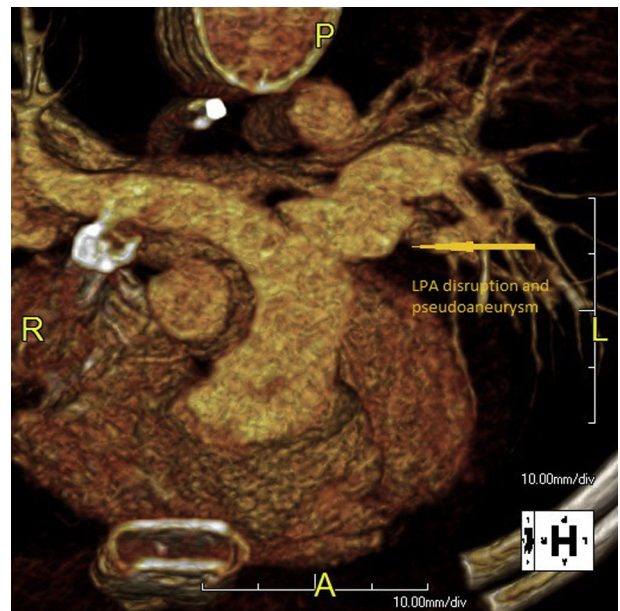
Gated chest computed tomographic angiogram demonstrating a  $1.9 \times 1.1 \times 2.6$ -cm contrast-filled outpouching, described as a moderate pseudoaneurysm, at the proximal left pulmonary artery (LPA), just beyond the bifurcation of the pulmonary arteries. Anteroposterior cranial view. RPA, Right pulmonary artery; MPA, main pulmonary artery.
